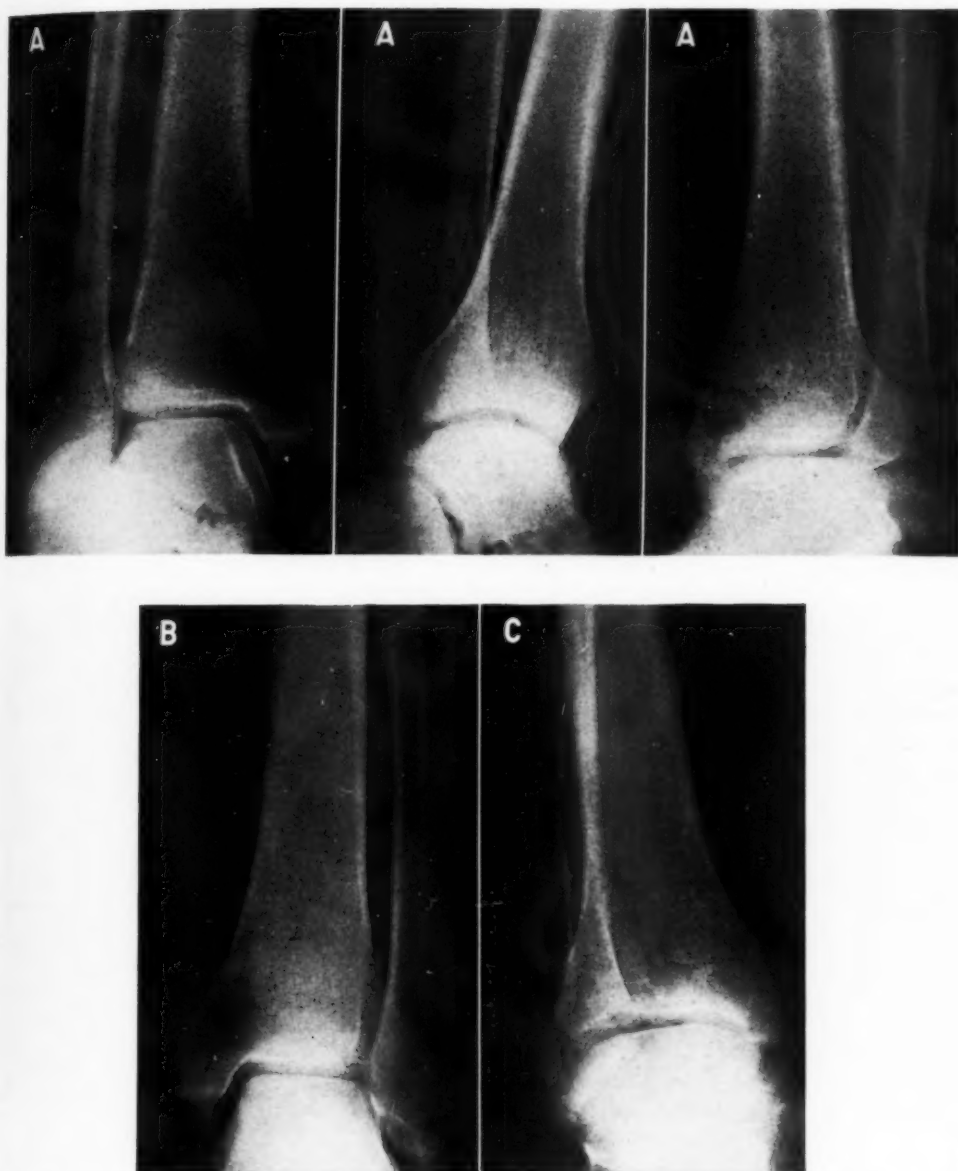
A. Anteroposterior fibulotibial, lateral, and postero-anterior tibiofibular oblique views of the left ankle fail to reveal any evidence of a fracture. B. Anteroposterior view showing a short, faintly visualized fissure; the x-ray beam here approached parallelism with part of the gap. C. Anteroposterior tibiofibular oblique projection. This is practically parallel with the long fissure fracture, which is properly visualized.
